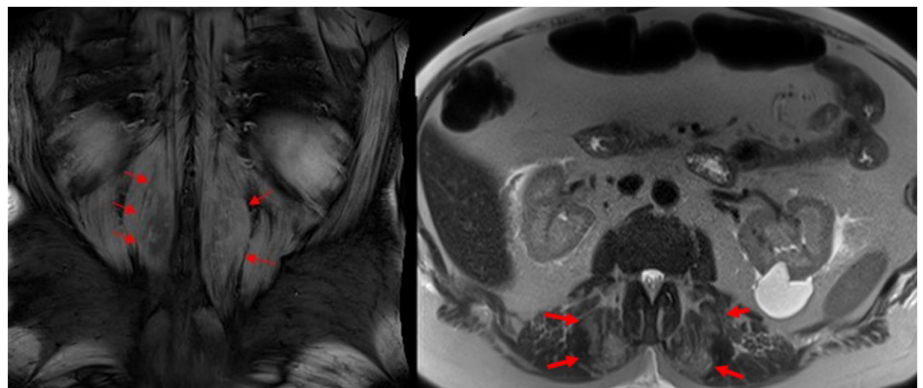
(A and B) Magnetic resonance imaging showing edema in the bilateral erector spinae musculature (axial and coronal sections).
